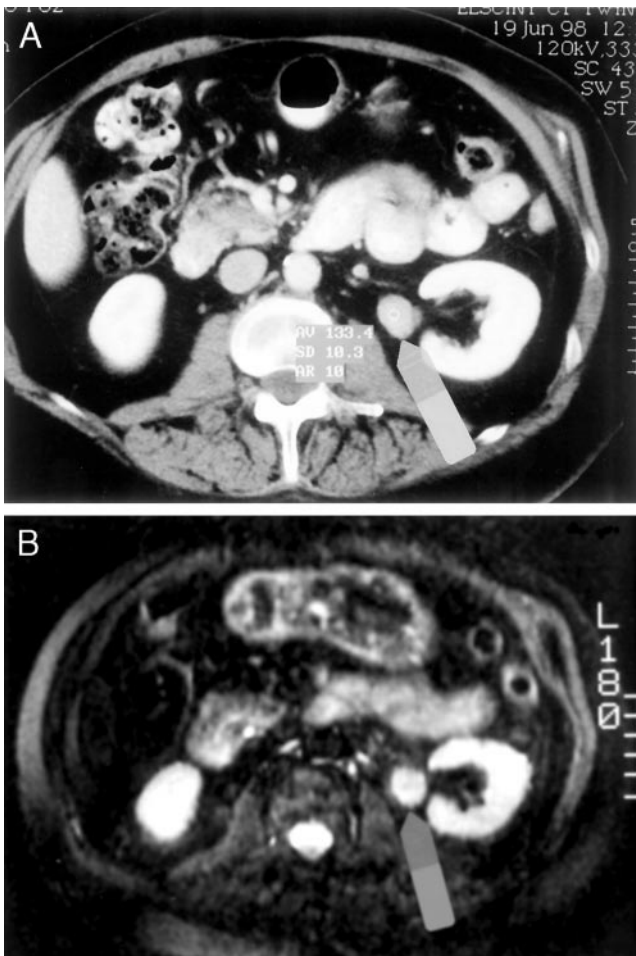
Recent CT (A) and MRI (B) of the abdomen showing growth in the lesion seen in Fig. 1 (arrow). The nodule was approximately 3.5 cm in diameter.
